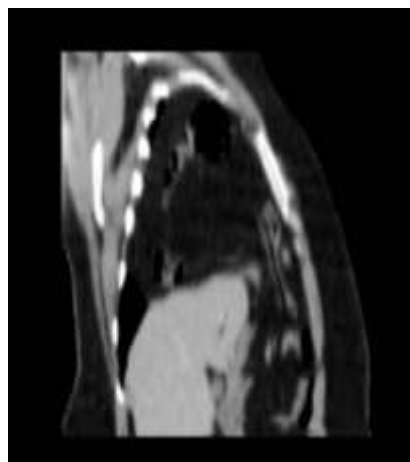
CT showed scans in sagittal reconstruction-Morgagni hernia involves the front part of the diaphragm
